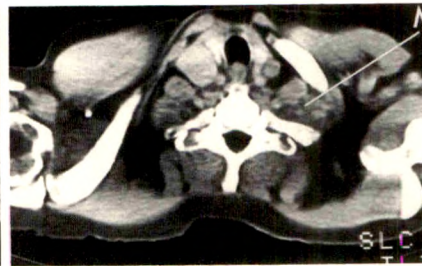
52-year-old woman with sarcoidosis and superior sulcus tumor. Axial CT scans reveal extension of mass (M) into supraclavicular fossa and involvement of brachial plexus.
